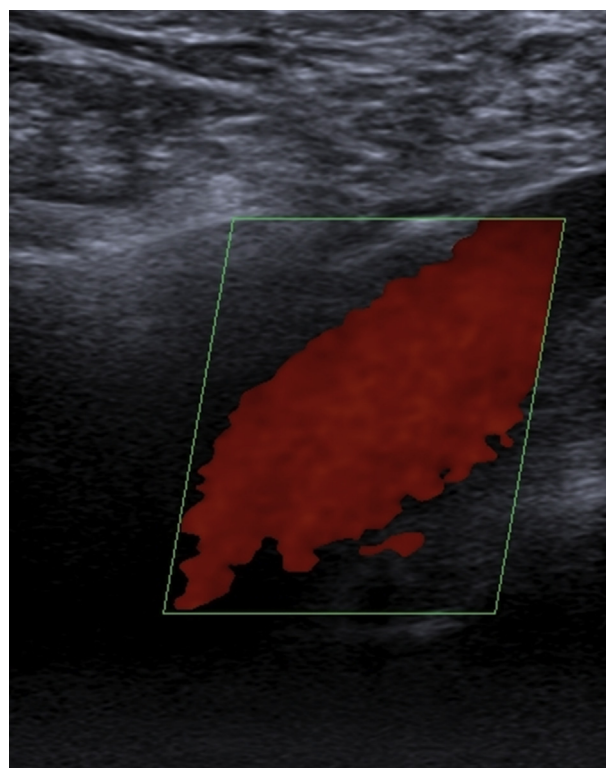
Doppler ultrasound (DUS) scan at 4 years of follow-up showing patency of the external iliac vein (EIV) in the absence of recurrence.
